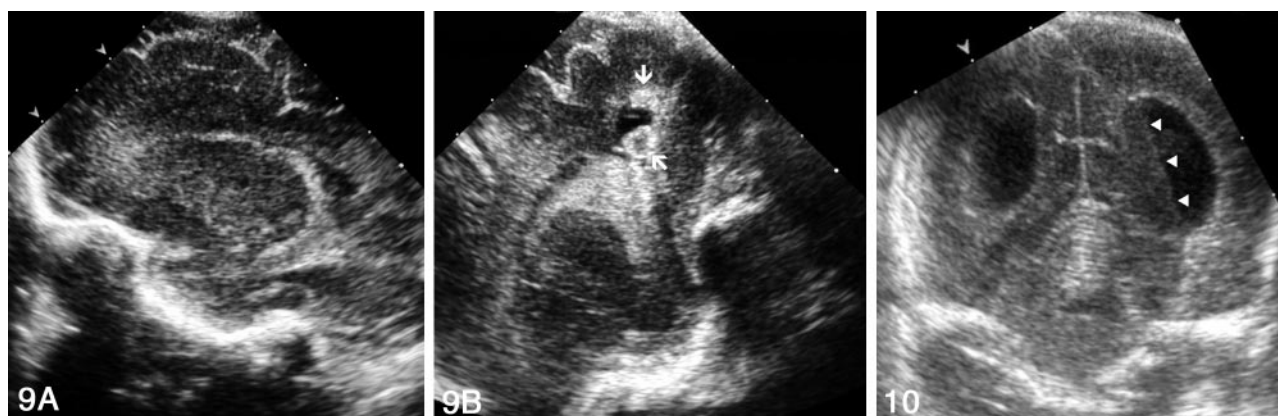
Sonograms obtained in a premature neonate with grade II intraventricular hemorrhage.
